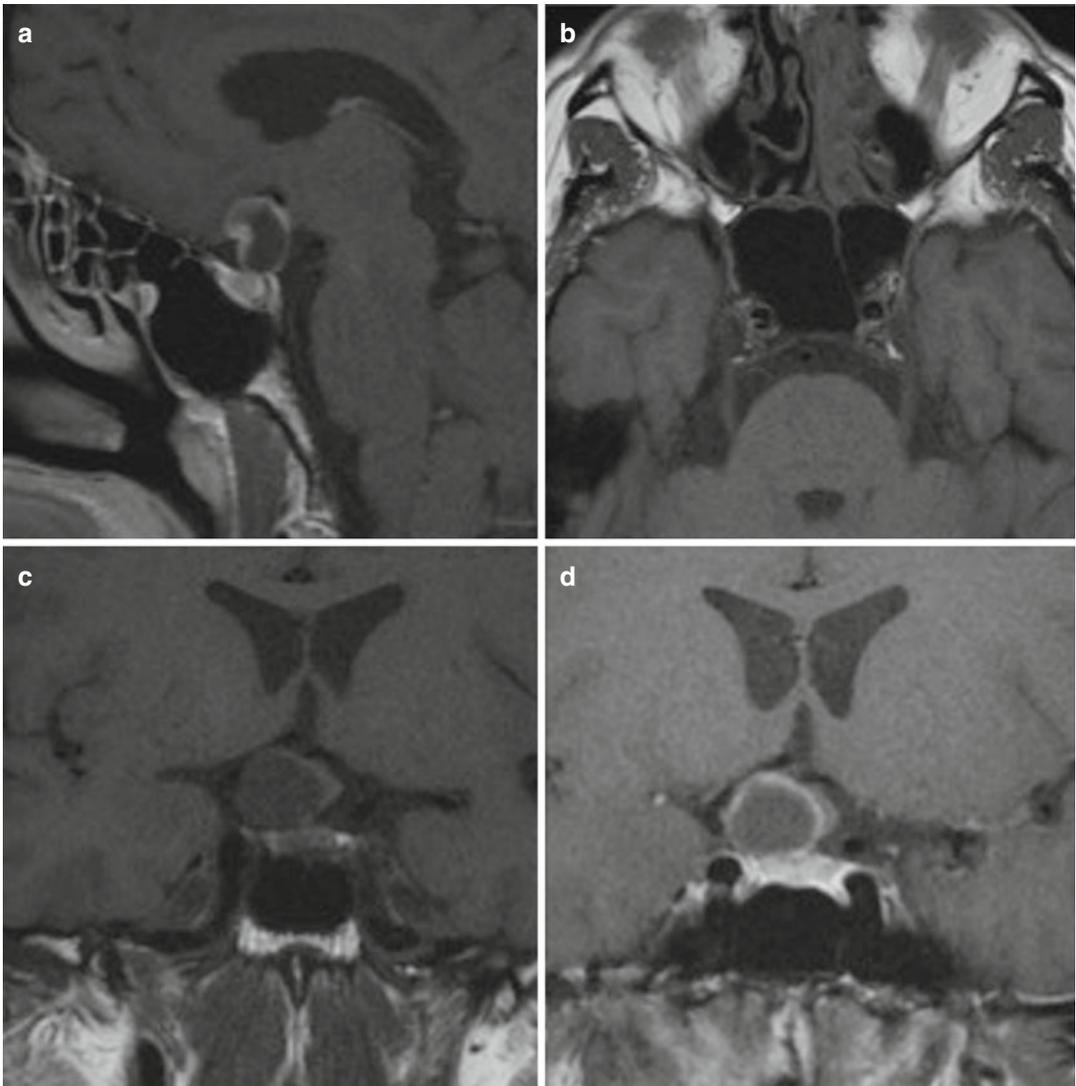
(a) Sagittal post-contrast T1-weighted images showing a very well-pneumatized sphenoid sinus, (b) axial T1-weighted images showing the sphenoid septum that deviates to the left leading straight to the internal
